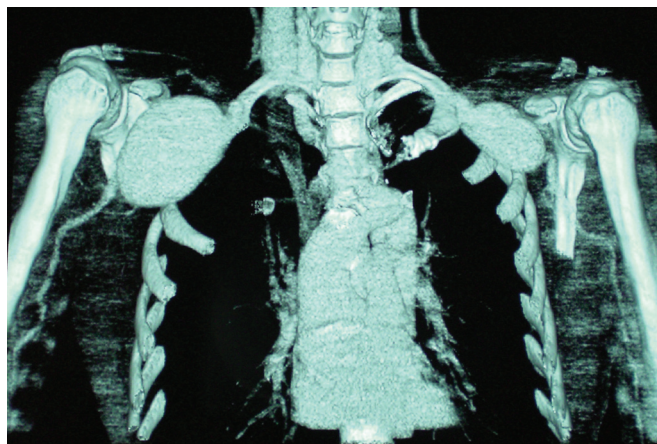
Preoperative computed tomography angiography image showing bilateral axillary artery aneurysms (anterior view).
